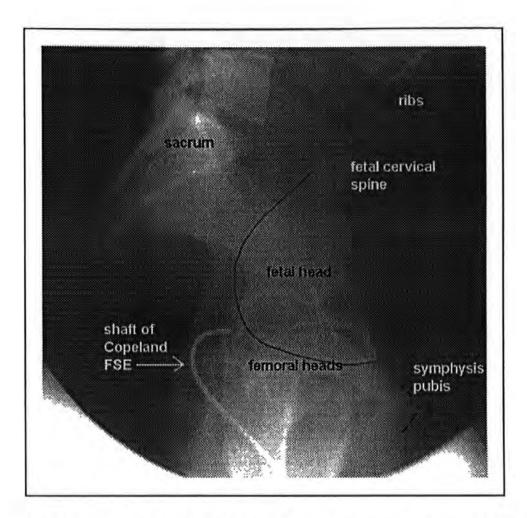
A serendipitous X-ray taken in early labour (because of a mistaken diagnosis of a breech presentation). A Copeland FSE has been applied to the fetal head. There is a gap between the fetal head and the shaft of the FSE because the plastic head of the FSE is not visible on the X-ray. Note the curve on the shaft of the FSE as it follows the axis of the vagina which is likely to cause tension at the electrode/scalp interface.
